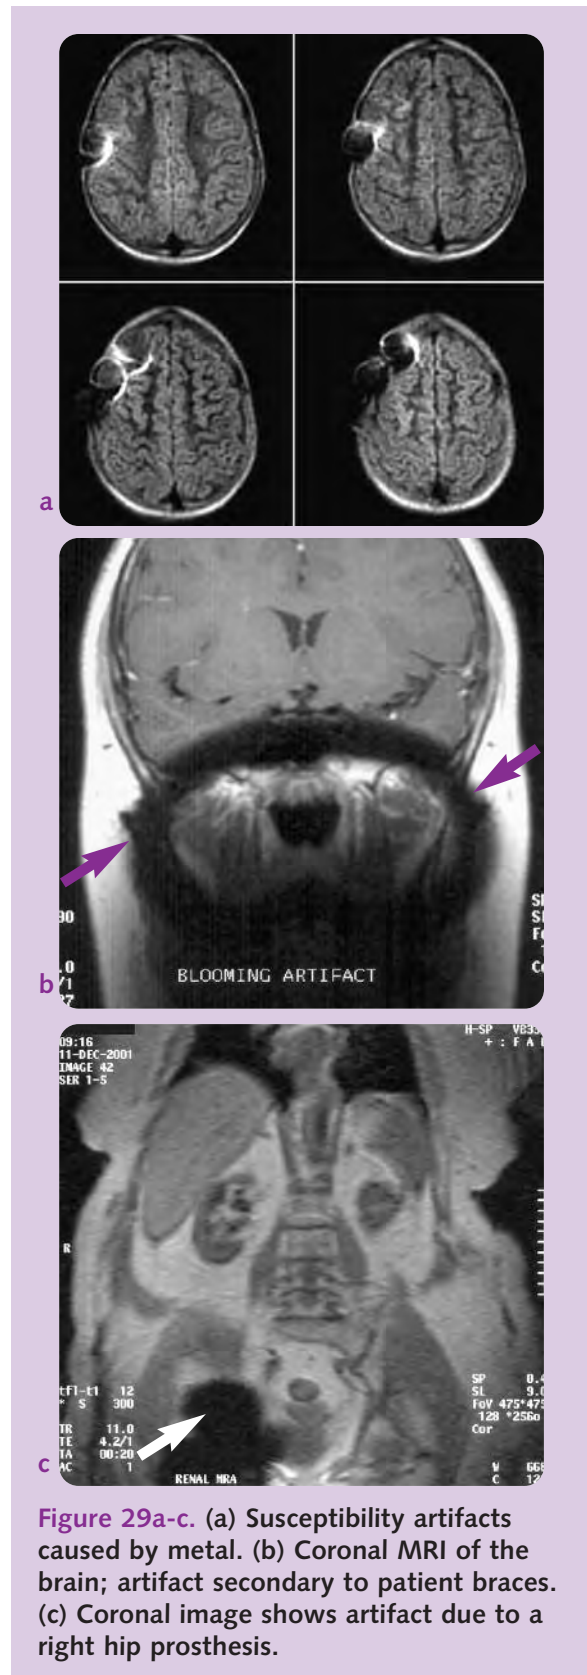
(a) Susceptibility artifacts caused by metal. (b) Coronal MRI of the brain; artifact secondary to patient braces. (c) Coronal image shows artifact due to a right hip prosthesis.
